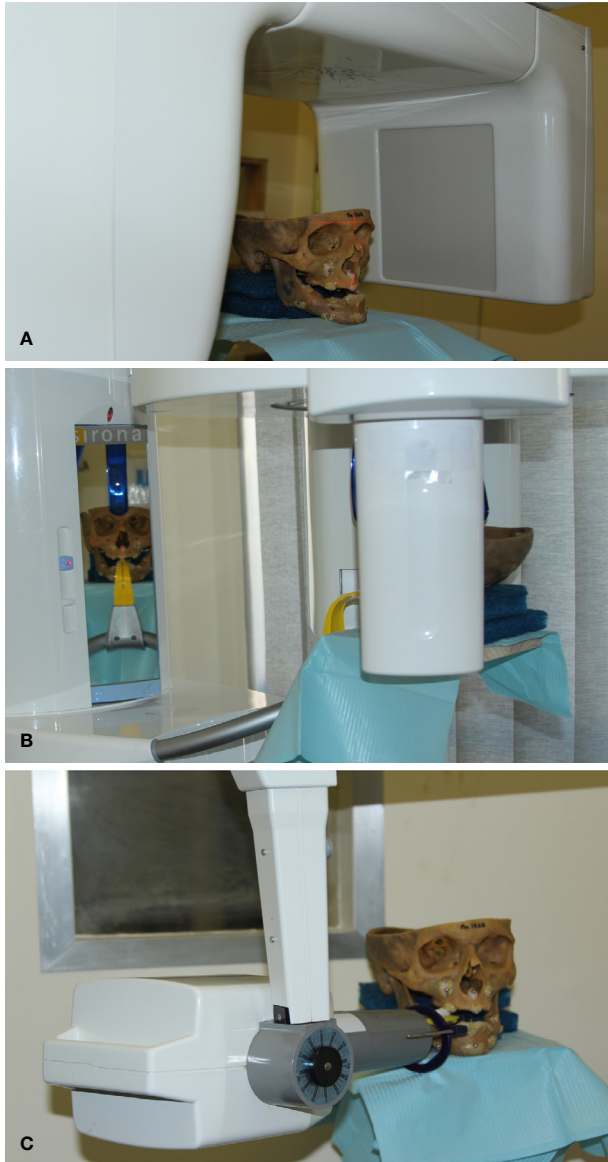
X-ray machines that were used (A) CBCT, (B) panoramic, and (C) periapical x-ray machines.
